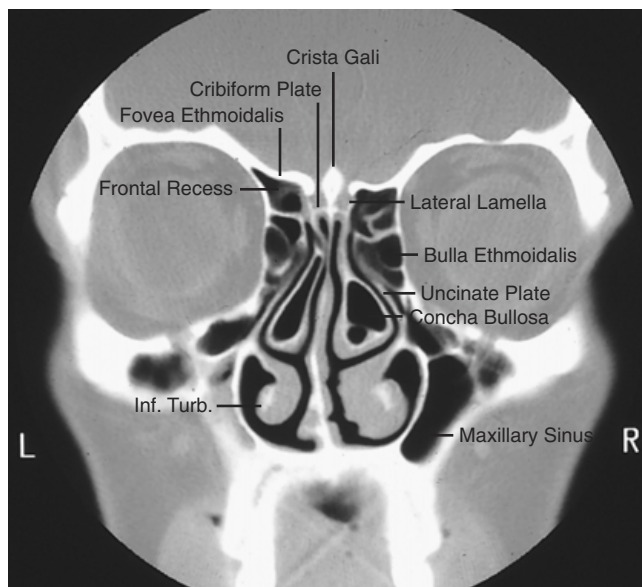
Computerized axial tomography (CAT) radiograph of the nose. Coronal section view of the osteomeatal unit. Note bilateral concha bullosa.
